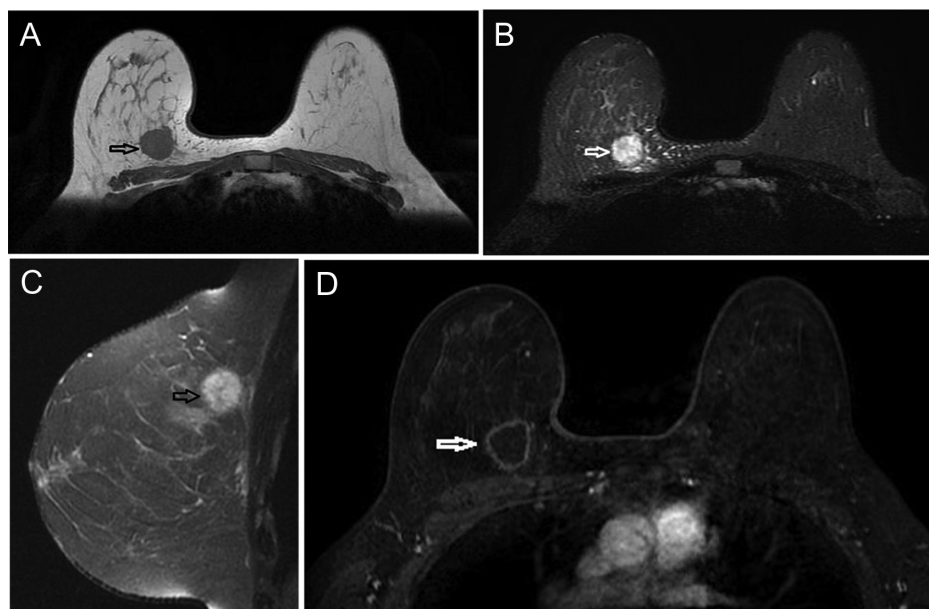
Triple-negative breast cancer is in a 45-year-old woman's right breast. T1-weighted (T1-W) (A) and T2- weighted (T2-W) with fat saturation (B) axial MR images show a 1.5-cm round mass with an irregular margin in the posterior location (black arrow in A and white arrow in B). Very high signal intensity mass and prominent peritumoral edema is seen in fat-saturated T2-W axial image. Hyperintense mass (C) is also seen adjacent to the pectoral muscle (black arrow) in the same sequence at sagittal view. The T1-W subtraction image (D) reveals the mass with rim enhancement (white arrow).
